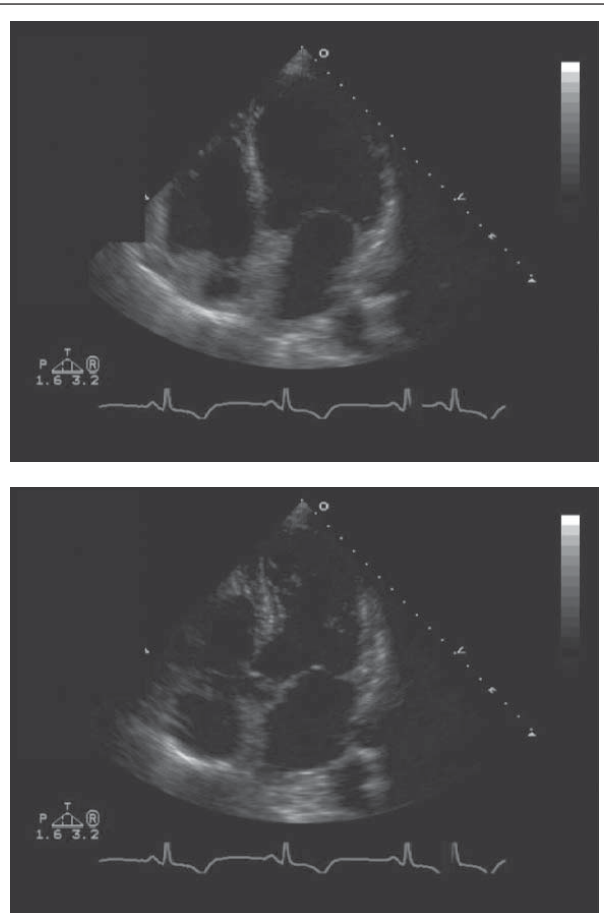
Transthoracic echocardiogram with apical 4-chamber views of the patient during her acute illness demonstrating basal hyperkinesis and apical dyskinesia. Diastole is above and systole is below.
